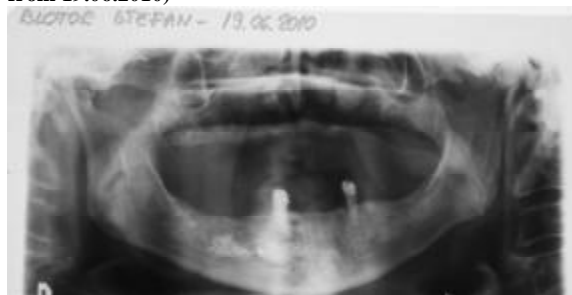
Zone of regeneration with bone apposition extending over the whole area of the former cystic cavity, radiopaque images and absence of 4.4 (X-ray image dating from 19.06.2010)
